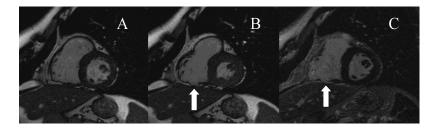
Diastolic (A) and systolic (B) short axis cine MR images show dyskinesia of the right ventricular free wall and the inferior wall of the right ventricle (arrows) in a 29-yr-old male patient (patient no. 7). The inversion-recovery turbo FLASH sequence shows late enhancement in the same wall segments.
